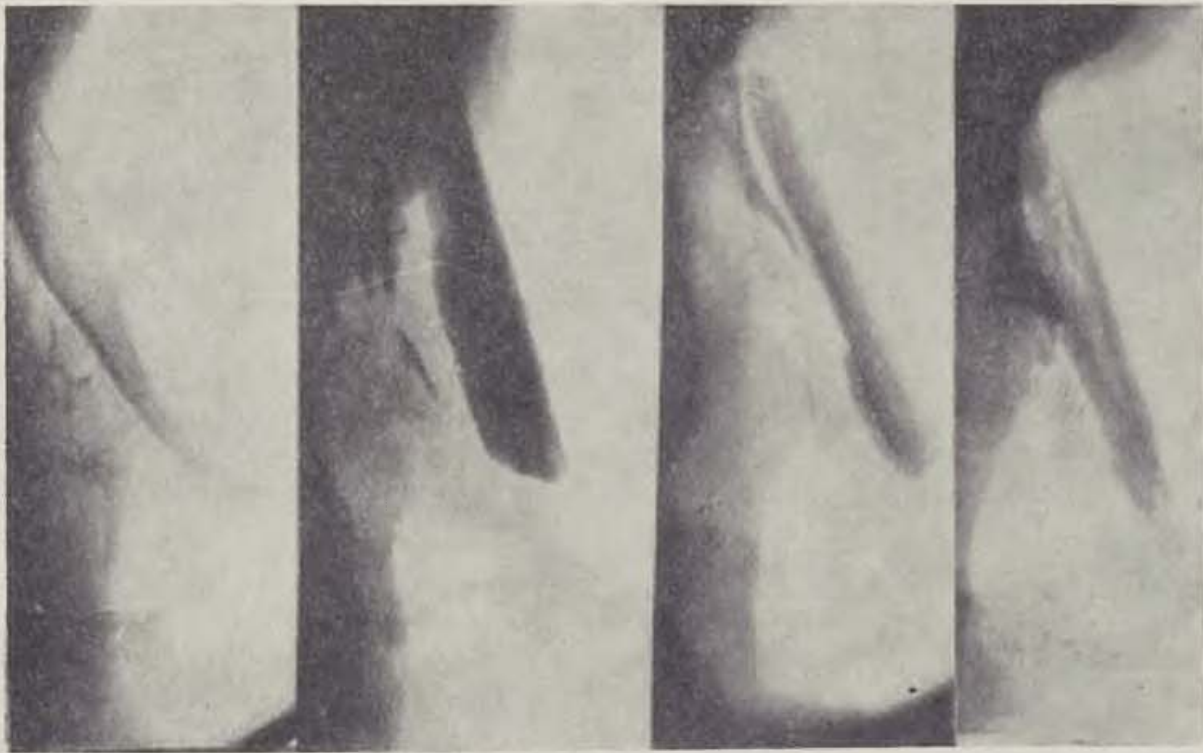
Radiographs made after transplantation
